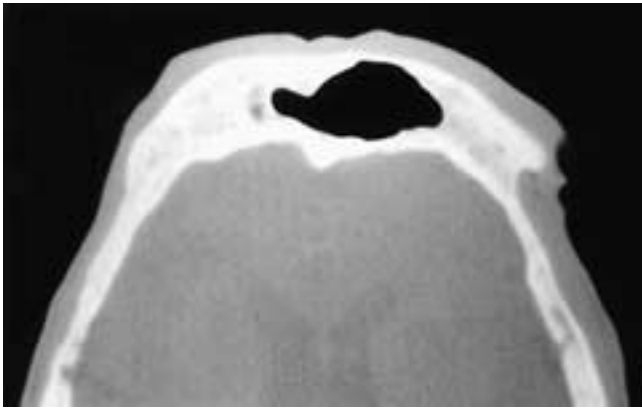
Axial CT scan shows an expanded left frontal sinus in a patient with a thick, cortical-type calvarium. The sinus mucosa is normal. This patient had acromegaly.
